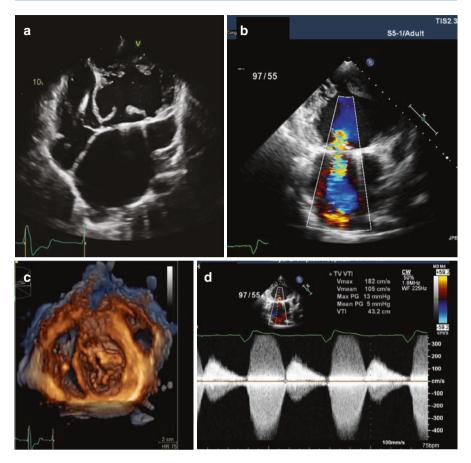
Transthoracic echo of 34-year-old with CCTGA and previous (unsuccessful) repair of systemic AV valve. (a) Massively dilated LA and RV with ring from previous valve repair. Pacing lead noted in LV. (b) Severe systemic AV valve regurgitation (tricuspid valve). (c) Short axis of systemic AV valve—trileaflet valve with thickened abnormal leaflets. (d) Severe Tricuspid regurgitation (systemic pressures)
